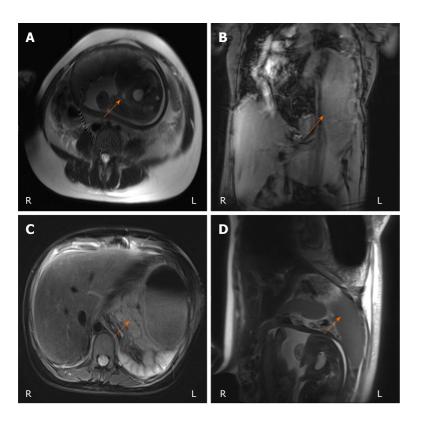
Magnetic resonance imaging findings. A: Foetus in pregnancy; B: Diaphragmatic hernia; C: Pancreatitis; D: The position of the abdominal organs and tissues was changed.
